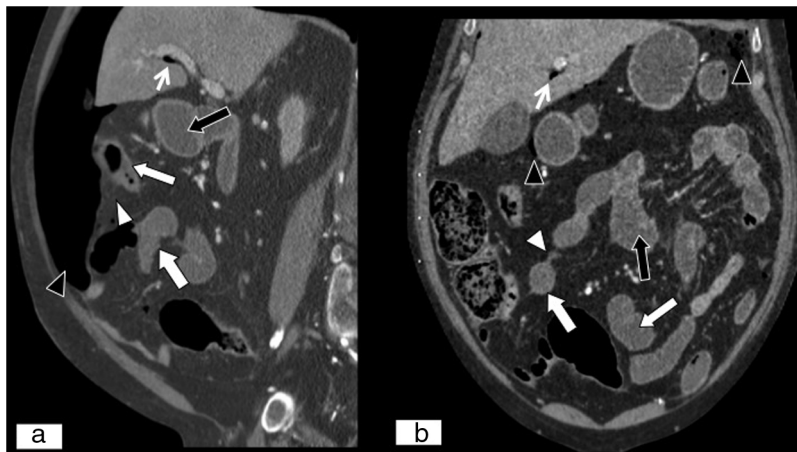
Ischaemic intestinal perforation. MPR on a sagittal plane (A) and MPR on a coronal plane (B), from an abdominal and pelvic CT scan with iodinated intravenous contrast in a portal phase. Loops of small intestine with abundant fluid content in relation to paralytic ileus (black arrows). Loops of small intestine with limited parietal uptake (white arrows) and a thin sheet of adjacent free liquid (white arrow tips). Pneumoperitoneum (black arrow tips) and periportal gas (thin white arrows).
